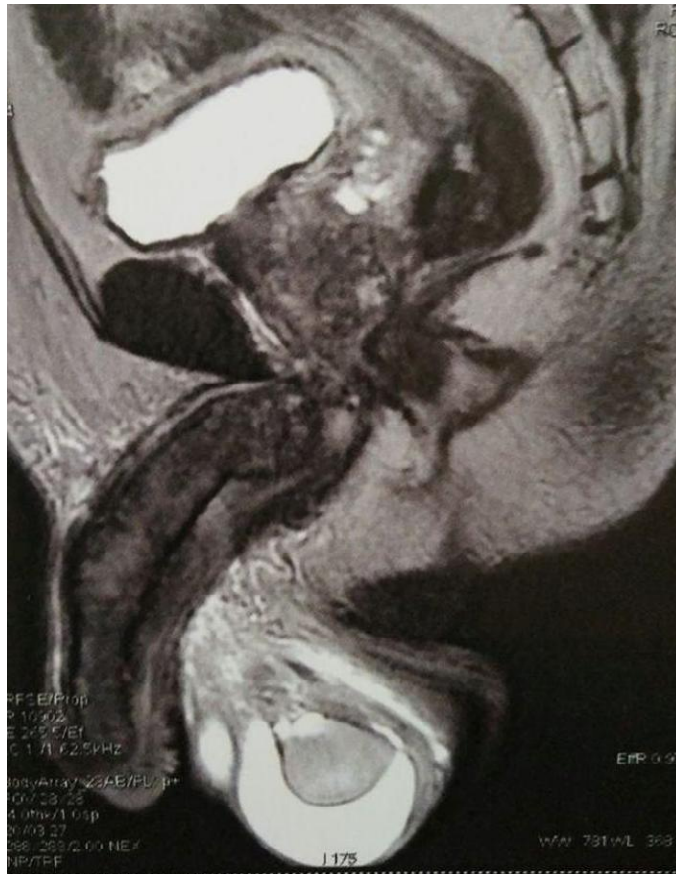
Pelvic MRI showing involvement of cavernosae corporea and spongiosus
